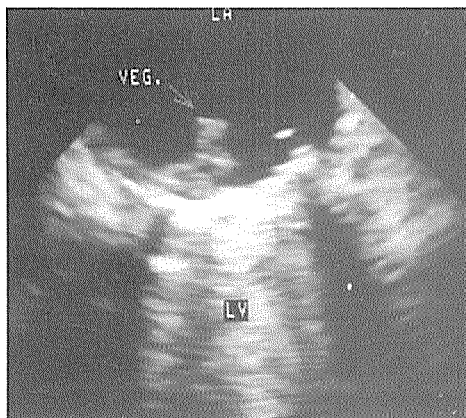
Transesophageal echocardiogram at the level of the left atrioventricular junction. A bilcaflet prosthetic valve is in mitral position, which casts a shadow within the left ventricle (LV). There is a vegetation (arrow) of the left atrial side of the prosthesis. LA = left atrium. The vegetation was not seen at transthoracic study because of shadowing of mitral prosthesis in the left atrium.
